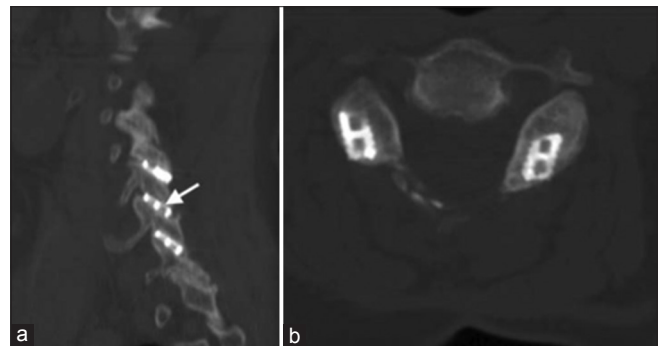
Sagittal computed tomography scan (a) of the cervical spine obtained 12 months after surgery demonstrating evidence of bridging bone (arrow) with no evidence of cage migration or subsidence. Axial computed tomography scan (b) of the cervical spine obtained 12 months after surgery demonstrating location of cervical cage in relationship to the facet joint
